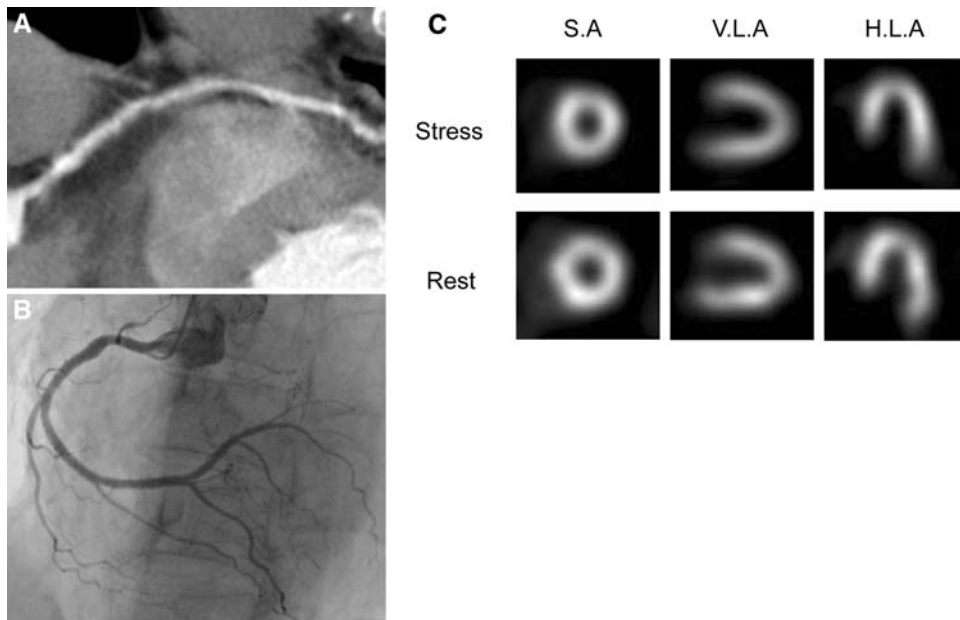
Results of a 60-year-old woman with chest pain. A, CTA shows a poor image with motion artifact in the RCA. B, Invasive coronary angiography shows no significant stenosis in the RCA. C, Corresponding nuclear myocardial perfusion imaging shows normal perfusion at peak exercise and at rest. Abbreviations as in Figure 1.
